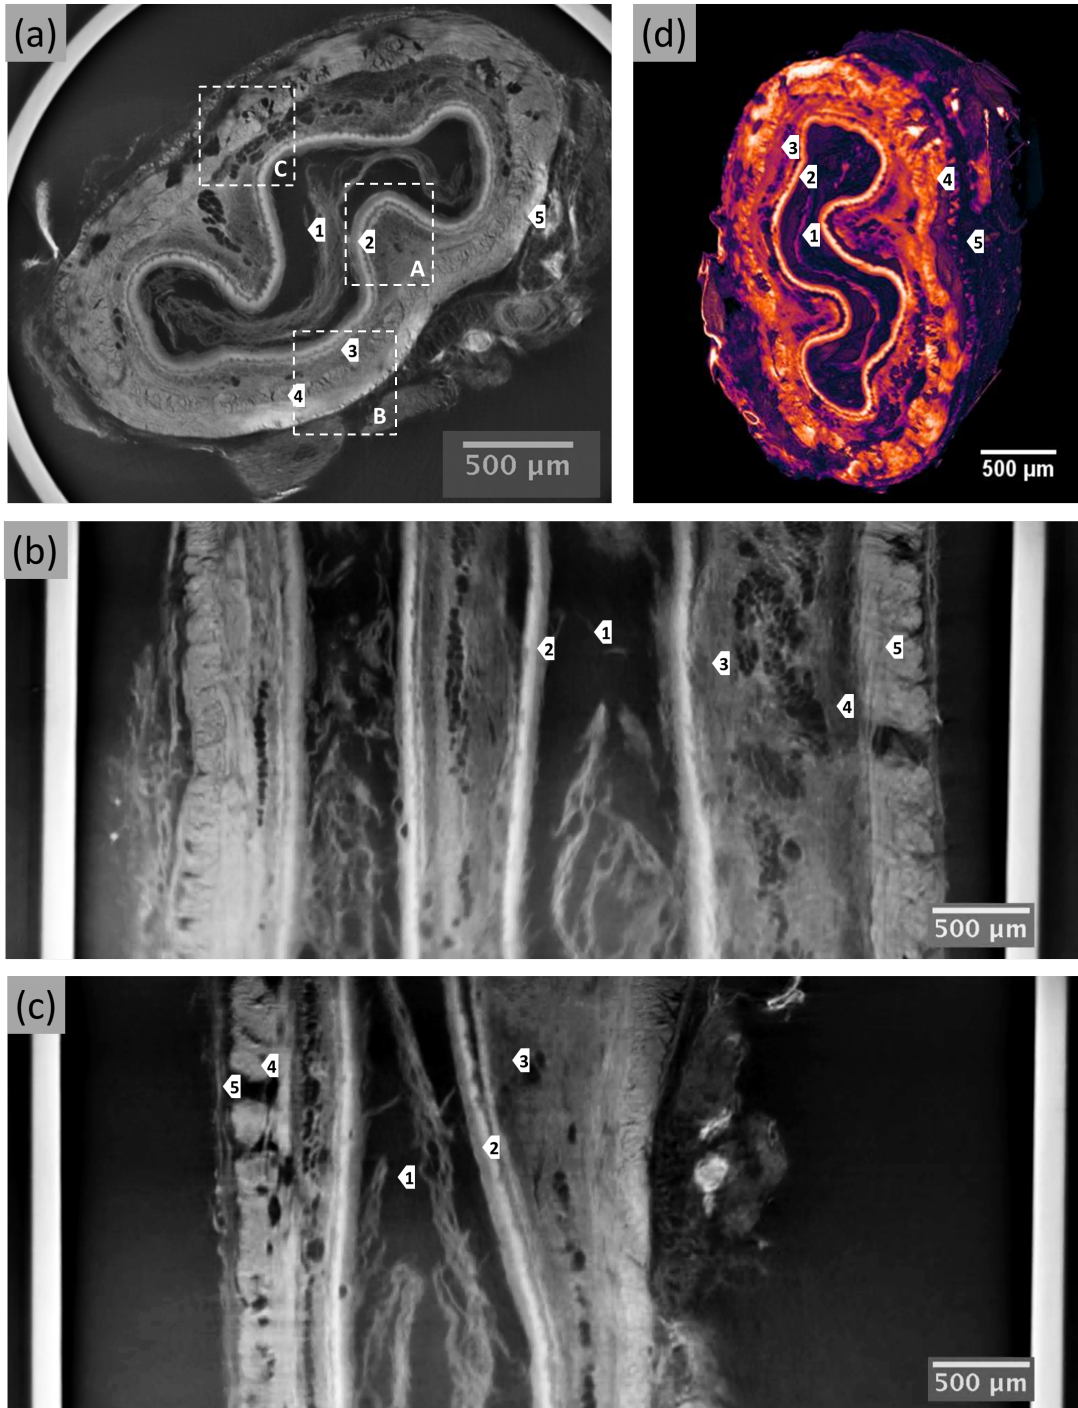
PC-CT images of the oesophagus acellular matrix: (a) transverse cross-section, (b) coronal cross-section, (c) sagittal cross-section and (d) volumetric rendering. The main structural components of the oesophagus are clearly visible and labelled 1. Lumen, 2. Mucosa, 3. Submucosa, 4. Muscularis Propria and 5. Adventitia.
